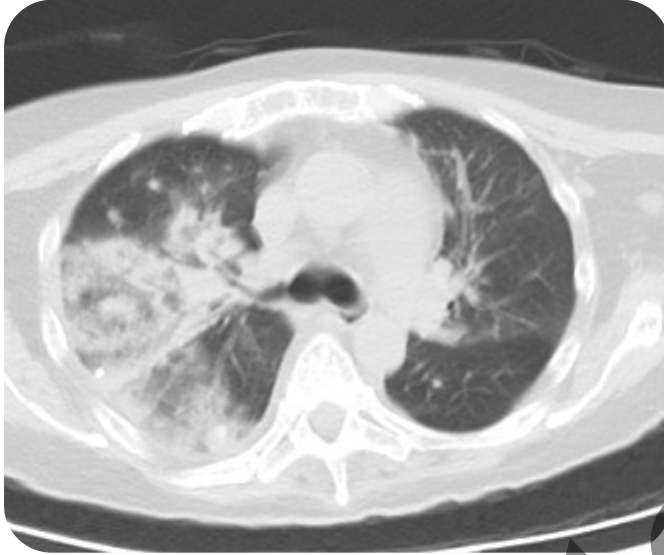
Chest computed tomography revealing patchy, nodular consolidations predominantly in the right upper and middle lung zones, consistent with invasive fungal pneumonia. These findings, in the context of profound neutropenia, raised strong suspicion for pulmonary aspergillosis.
